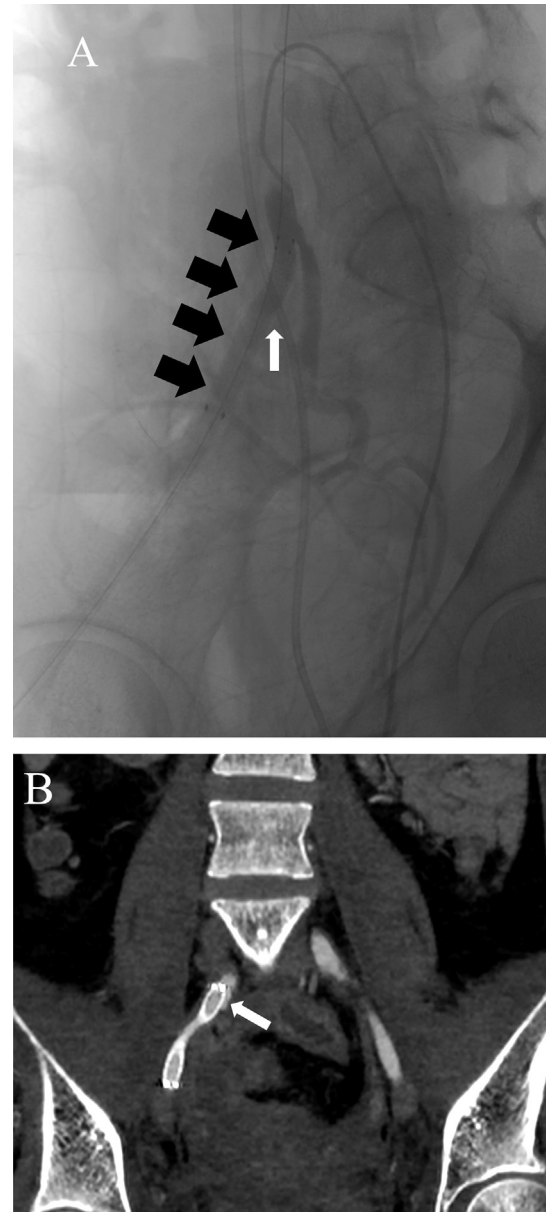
(A) A 6 × 50 mm Viabahn stent-graft (black arrows) was placed so that the right external iliac artery could seal the suspected ureteroarterial fistula (white arrow). (B) Contrast-enhanced computed tomography (CECT) image obtained 20 months after placement of a stent-graft revealed a pseudoaneurysm (white arrow) with periarterial soft tissue thickening at the proximal edge side of the stent-graft, which was at the origin of the right external iliac artery.
